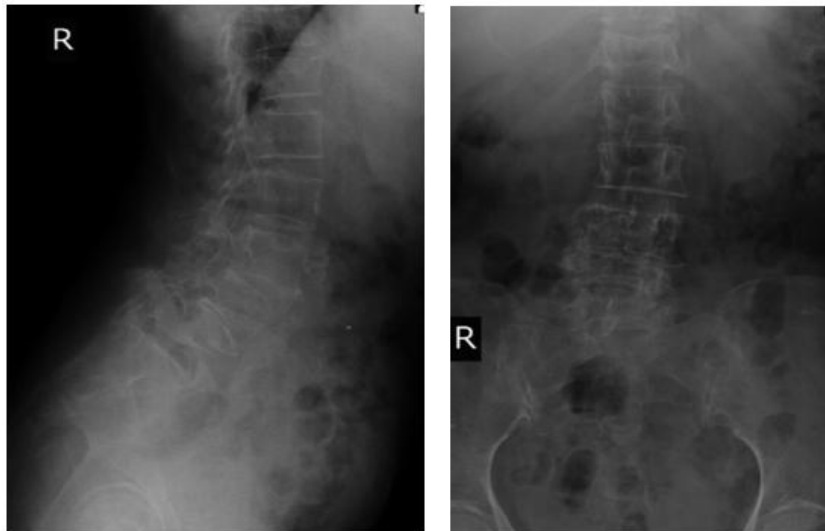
Pre-op X-ray lumbosacral spine antero-posterior and lateral view
